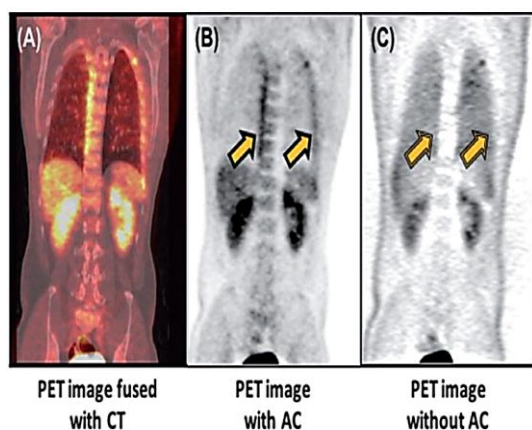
Artifacts when a Patient Shifted Between CT and PET Scans. A) In the PET/CT Fused Picture, Elevated Tracer Uptake is shown at one Side of the Lung Borders; B) Increased Uptake Value At Lung Borders in a PET Picture with CT-Based Attenuation Correction (arrows); C) Elevated Uptake is not Seen at the Same Sites (arrows) in the PET Picture without Attenuation Correction.
